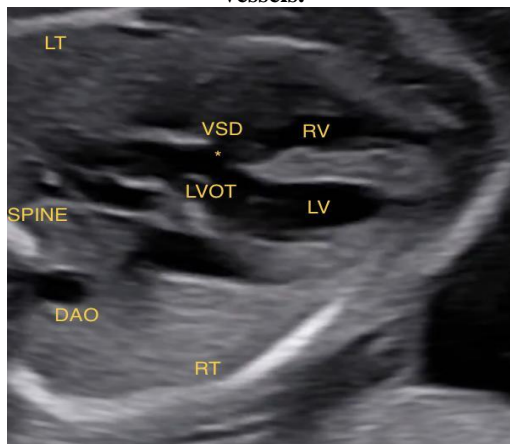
Fetal echocardiography showing ventricular septal defect (VSD) (*).
